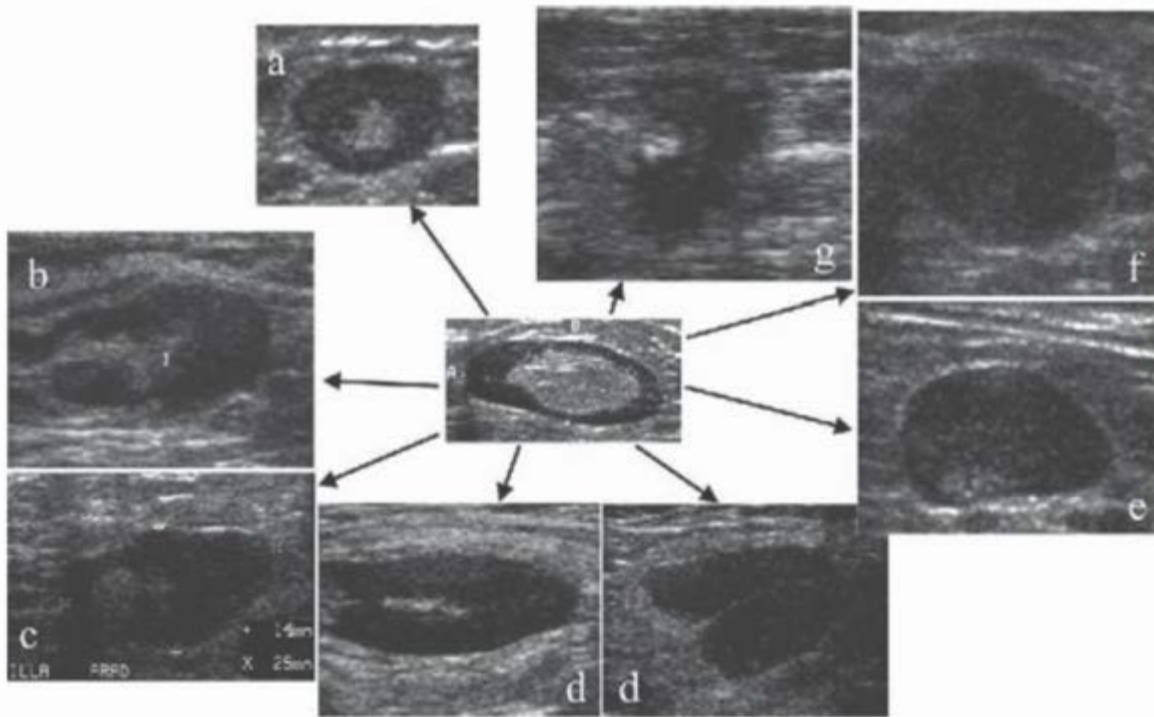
Range of abnormal sonographic lymph node appearances. (Reproduced with permission from Starvos TA. *Breast Ultrasound*. Philadelphia, PA: Lippincott Williams & Wilkins, 2003.)
